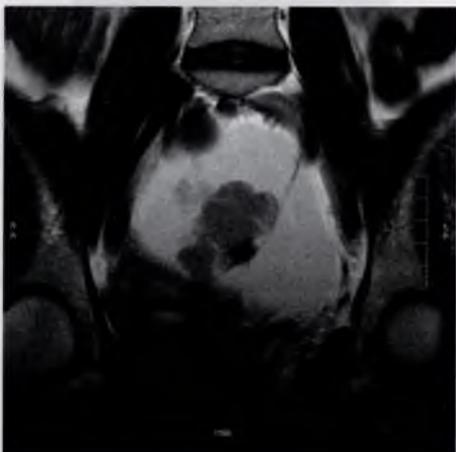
T2-weighted coronal scans showing a large predominantly cystic mass in the pelvis containing septations and solid components typical of an ovarian carcinoma. The uterus and cervix can be seen inferior to the mass and are separate from it.
